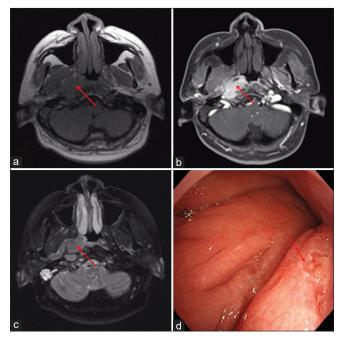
Representative images of the head-and-neck magnetic resonance imaging and nasopharyngoscopy. (a) The submucosal lesion exhibited isointense T1 signals on T1-weighed images (arrow). (b) After contrast scanning on T1-weighed image, the tumor was obviously enhanced (arrow). (c) The signal intensity of the tumor revealed a slightly long T2 on the T2-weighed image (arrow). (d) Nasopharyngoscopy revealed no remarkable abnormalities with the exception of thickening of the right torus, and the previous biopsy site can be seen on it (arrow)
